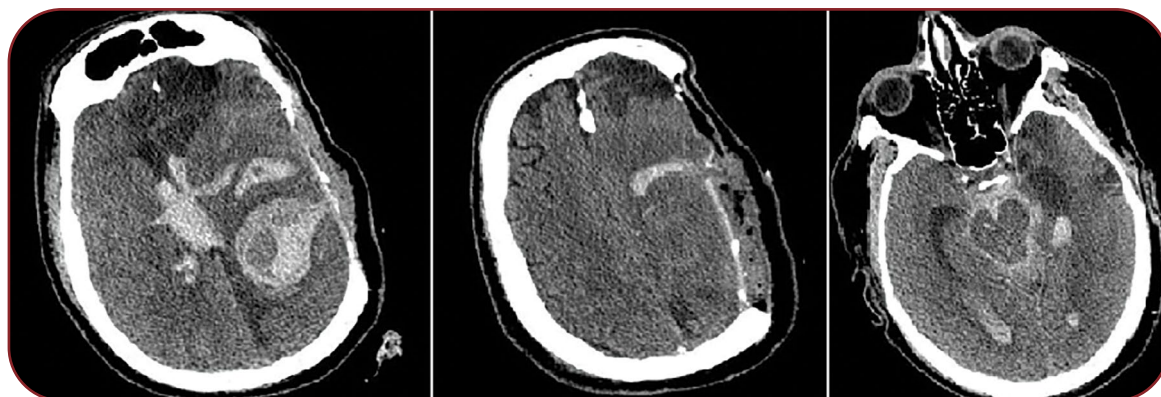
Head computed tomography scan on admission showing massive intracerebral hemorrhage with diffuse intraventricular extension and subarachnoid bleeding caused by the stab injury through the pre-existing bone defect – the sites of dural penetration are also visible
